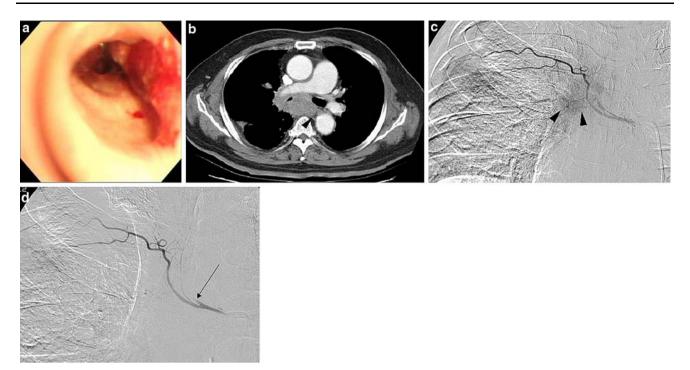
Images obtained in a 61-year-old man with well-differentiated squamous cell carcinoma who had suffered hemoptysis 1 day previously. A Bronchoscopy on that day reveals bleeding from the tumor in right upper lobe bronchus. B CT scan obtained just before arterial embolization shows tumor surrounding the right bronchus and right intercostobronchial artery (arrowhead). C There is
